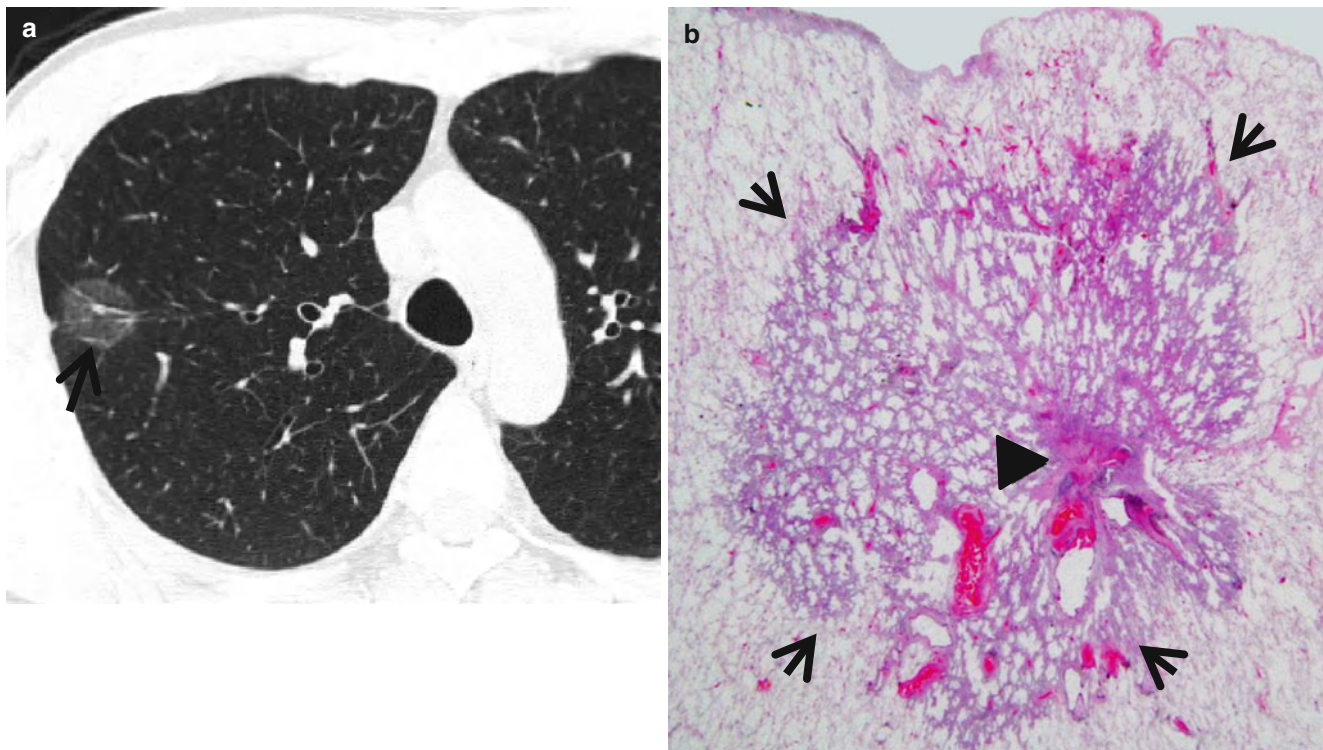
Adenocarcinoma in situ (former bronchioloalveolar carcinoma) in a 56-year-old man. (a) Lung window image of thin-section (1.5-mm section thickness) CT scan obtained at level of the azygos arch shows a 19-mm-sized ground-glass opacity nodule (arrow) in the right
